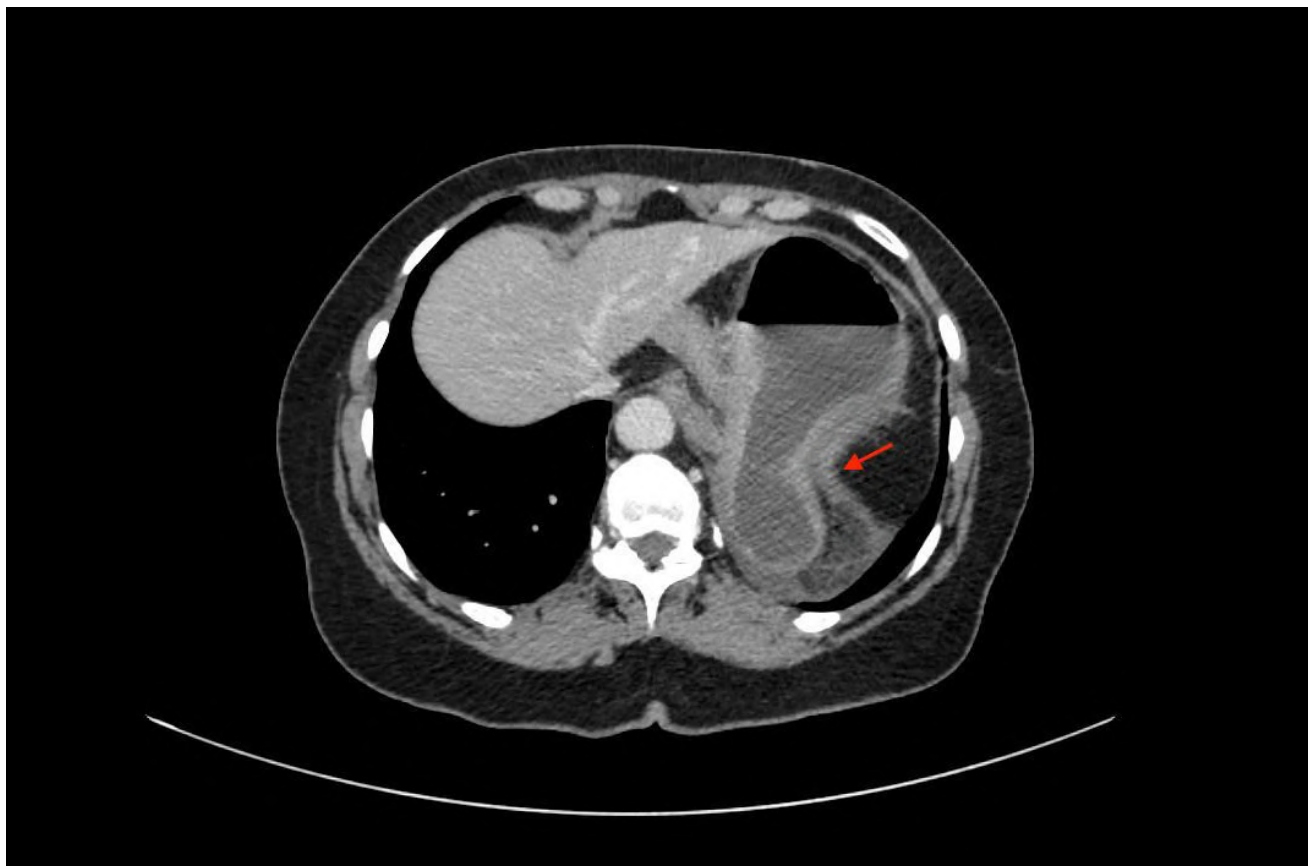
Preoperative CT scan case 2 showing incarcerated parahiatal hernia (arrow).
